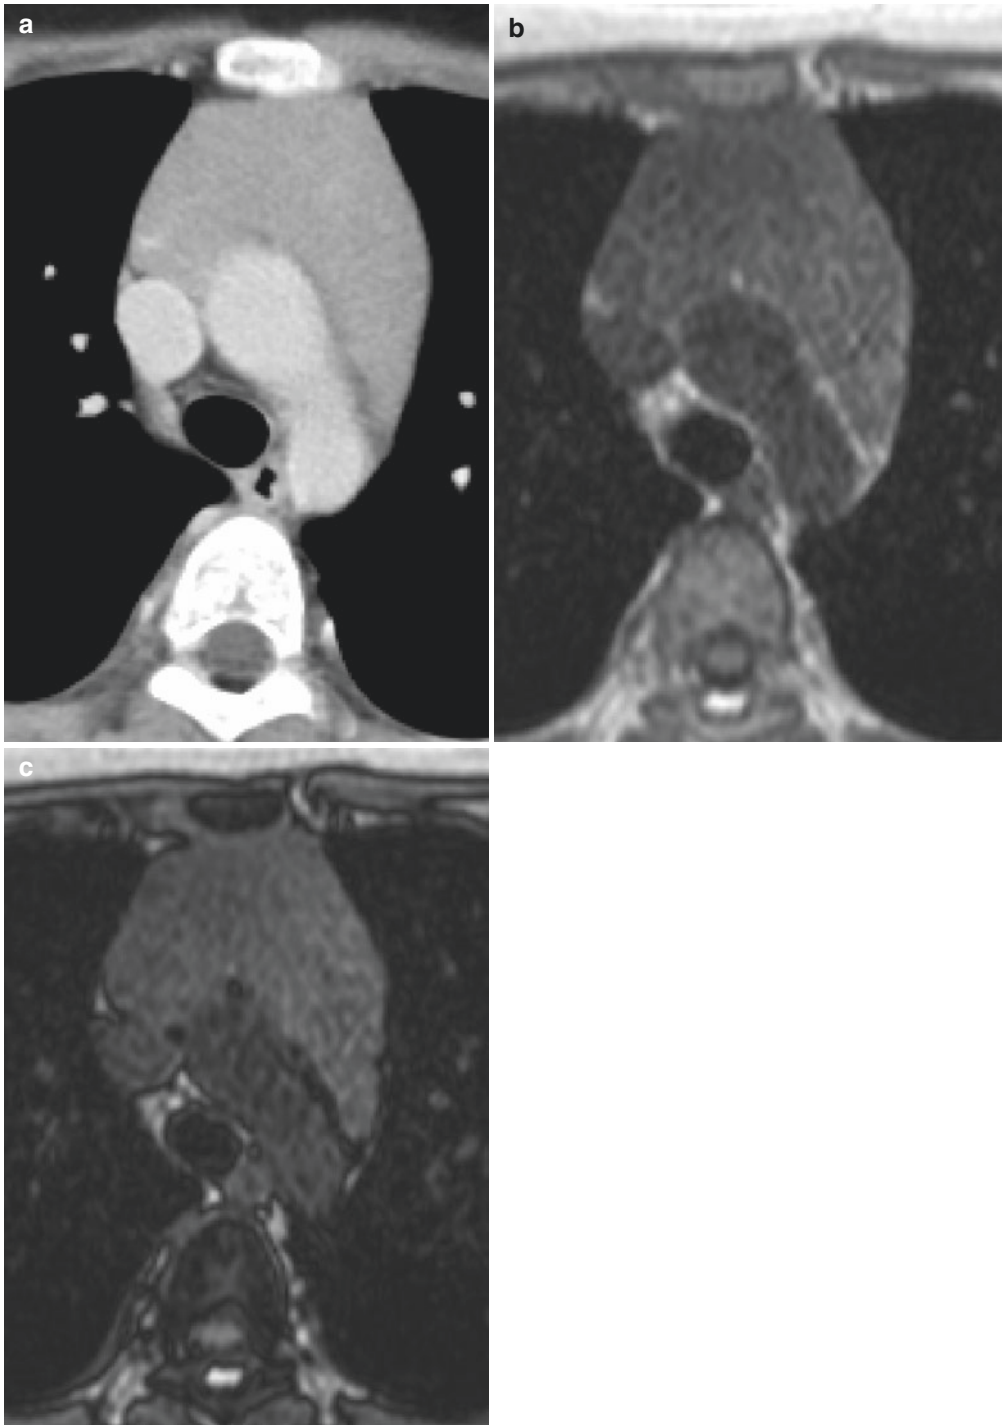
Rebound thymic hyperplasia in a 12-year-old patient with nodular sclerosis classical Hodgkin’s lymphoma after chemotherapy. Contrast-enhanced CT image (a) obtained 4 months after chemotherapy. Following shrinkage after chemotherapy, the thymus showed prominent enlargement. The findings are suggestive of rebound
